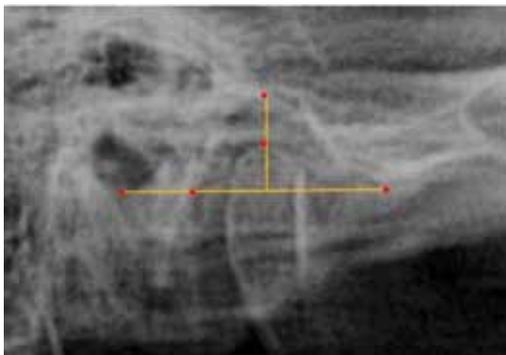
Measuring the basic linear dimensions on the temporomandibular joint radiograph on the right
